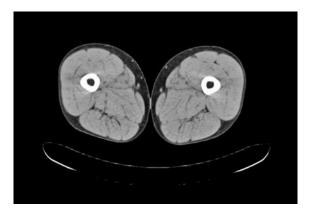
CT – slice at the level of the right femur shaft center
